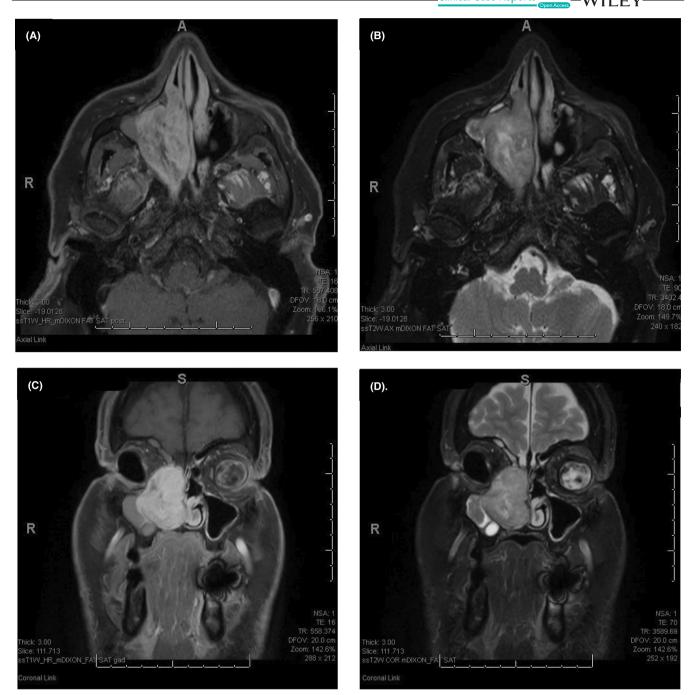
(A) Axial T1 fat saturated post-contrast magnetic resonance imaging of the face/paranasal sinuses. (B) Axial T2 fat saturated magnetic resonance imaging of the face/paranasal sinuses. (C) Coronal T1 fat saturated with gadolinium contrast magnetic resonance imaging of the face/paranasal sinuses. (D) Coronal T2 fat saturated magnetic resonance imaging of the face/paranasal sinuses. Imaging demonstrates findings of a right-sided sinonasal passageway lesion.
